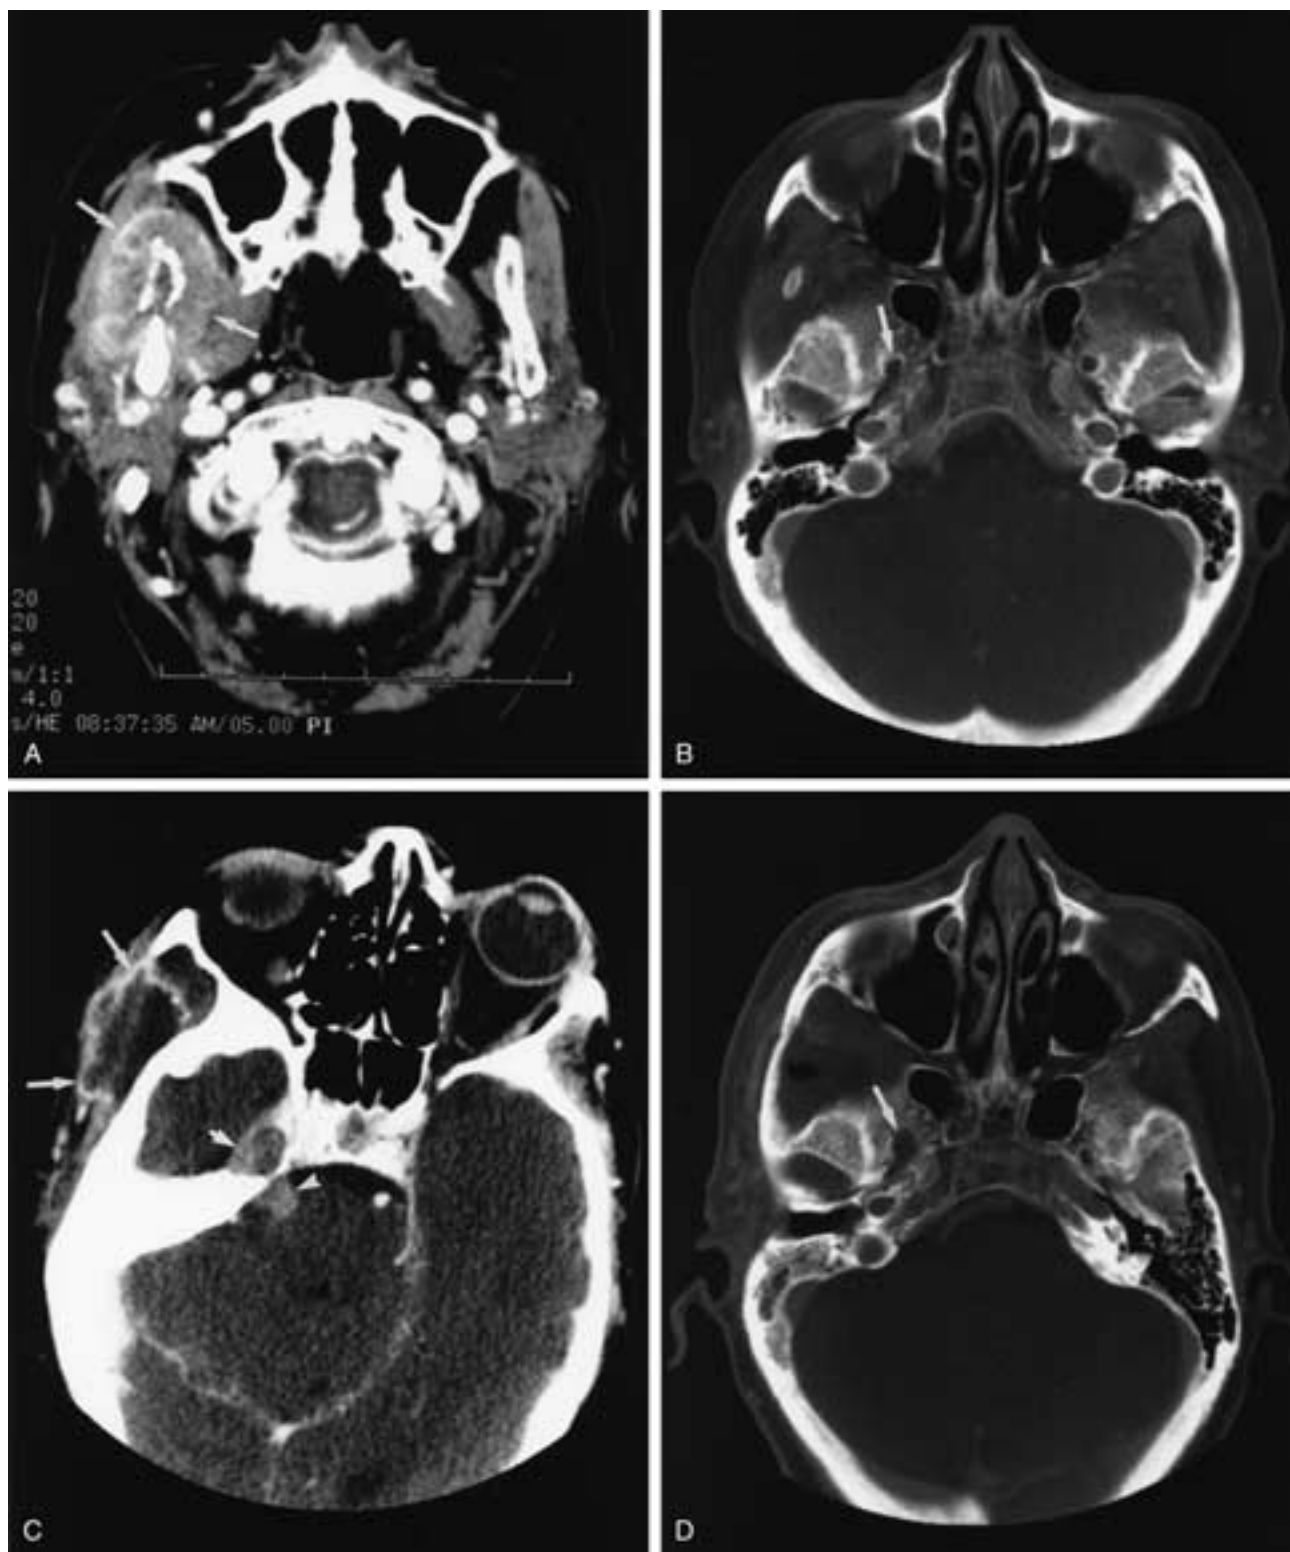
Squamous cell carcinoma of the right retromolar trigone with extension into the masticator space and subsequent PNS along V₃. Axial contrast-enhanced CT soft-tissue (A) and bone window (B) images at presentation show extensive tumor involvement of the right mandibular ramus and adjacent musculature (*arrows* in A). Note that the foramen ovale is normal, with intact cortical margins (*arrow* in B). No intracranial abnormality was visible on higher images at this time. Axial contrast-enhanced CT soft-tissue window (C) and bone window (D) images obtained 6 months after A and B. Despite surgery and radiotherapy, the patient had a large recurrence (*long arrows* in C). Note the enlargement and loss of the cortical margin in the right foramen ovale, suggesting PNS (*arrow* in D; compare this with the appearance of the foramen ovale in B). The soft-tissue window image shows enlargement and central enhancement indicating tumor in Meckel's cave (*short arrow* in C) with continued spread to involve the main right trigeminal trunk (*arrowhead*).
